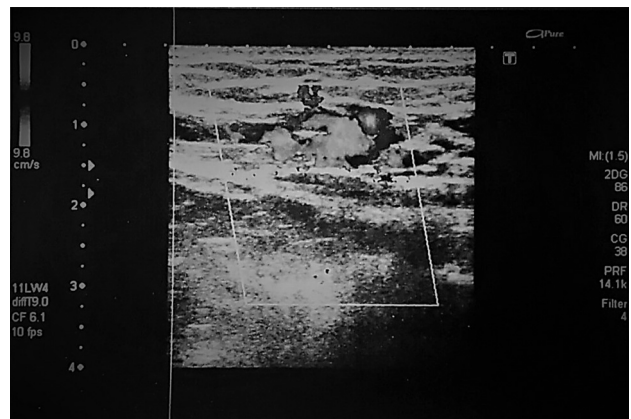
In Doppler ultrasonographic examination, it was seen that cystic lesions were filled with colors. Venous flow with low output was found in spectral samples.
